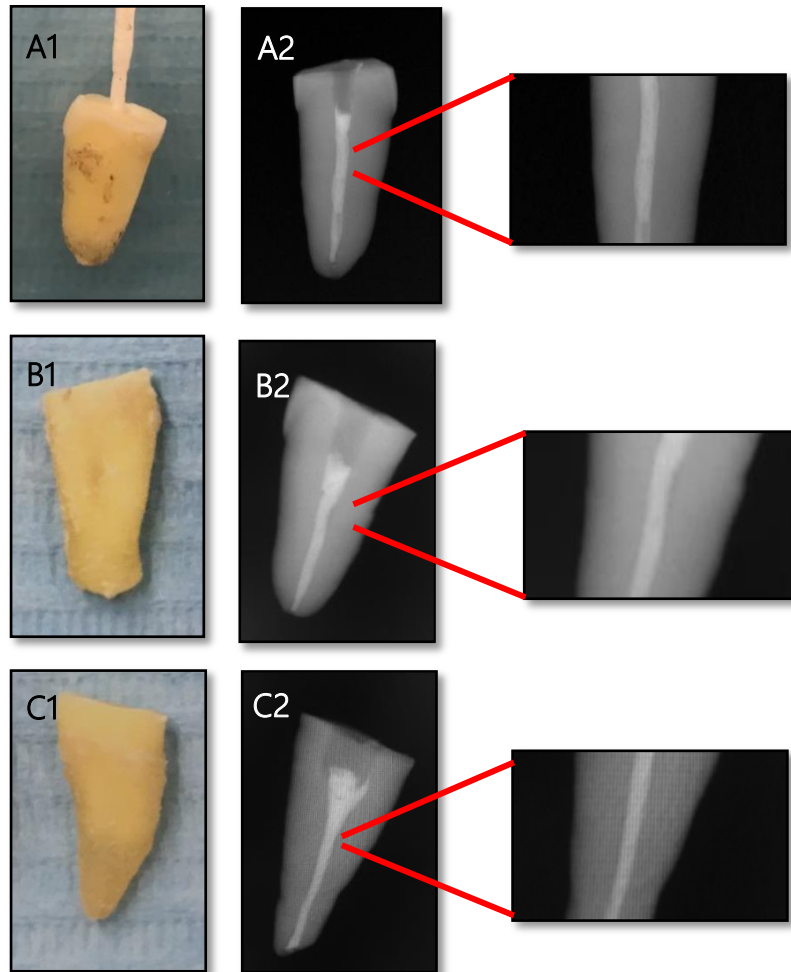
Macroscopic and X-ray digital images of extracted teeth filled with (A,B) SiMS-GP cones and (C) self-fabricated GP cone.
